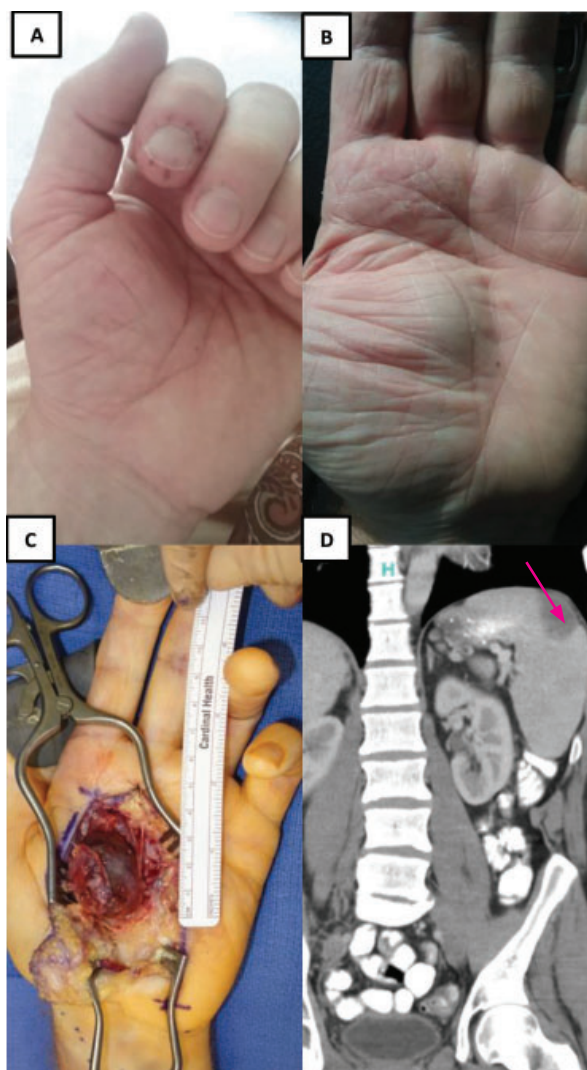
Findings before presentation: (A) painful periungual petechial rash on the left index finger; (B) pulsatile palmar mass; (C) intraoperative image of the aneurysm arising from the superficial palmar arch; and (D) abdominal computed tomography showing a wedge-shaped splenic infarct (arrow).
